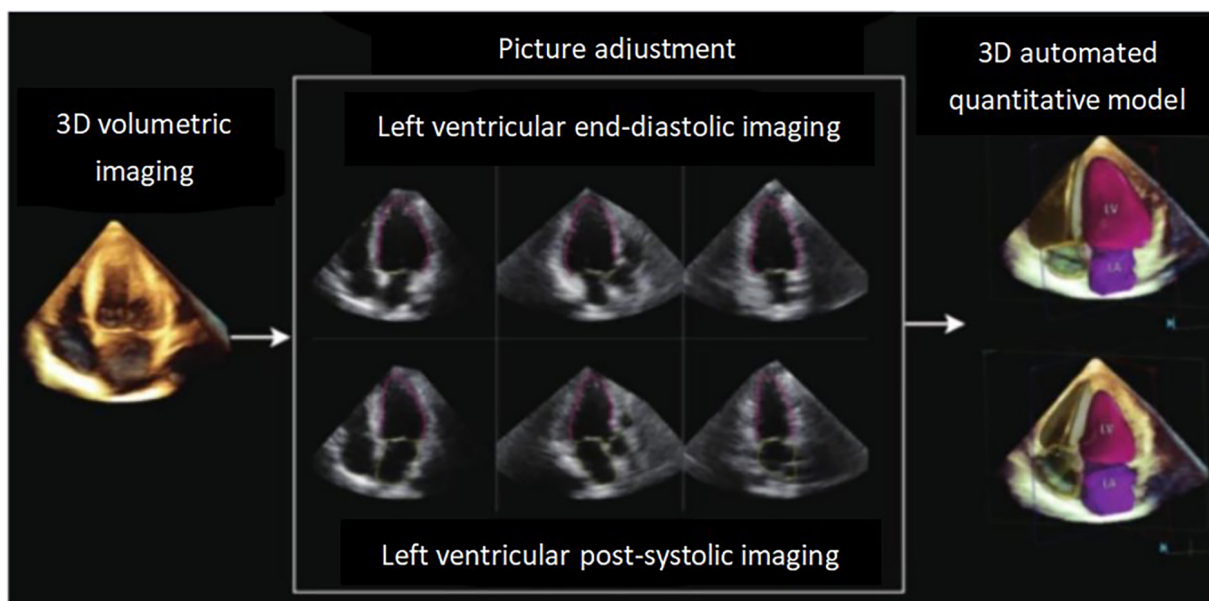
Evaluation of cardiac function after percutaneous coronary intervention (PCI) by using the three-dimensional echocardiography (3DE) technique.
